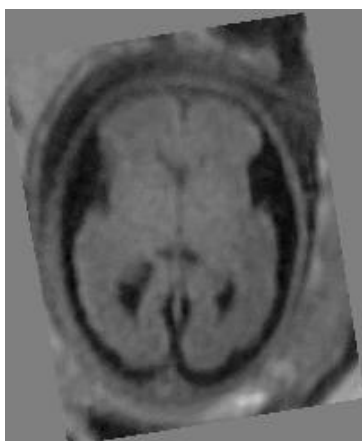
Axial FLAIR fetal brain image acquired using TR 2700, TE 122, bandwidth 41, echo train length 240, inversion time 2000, NEX 0.5, slice thickness 5mm, matrix 224 x 224
